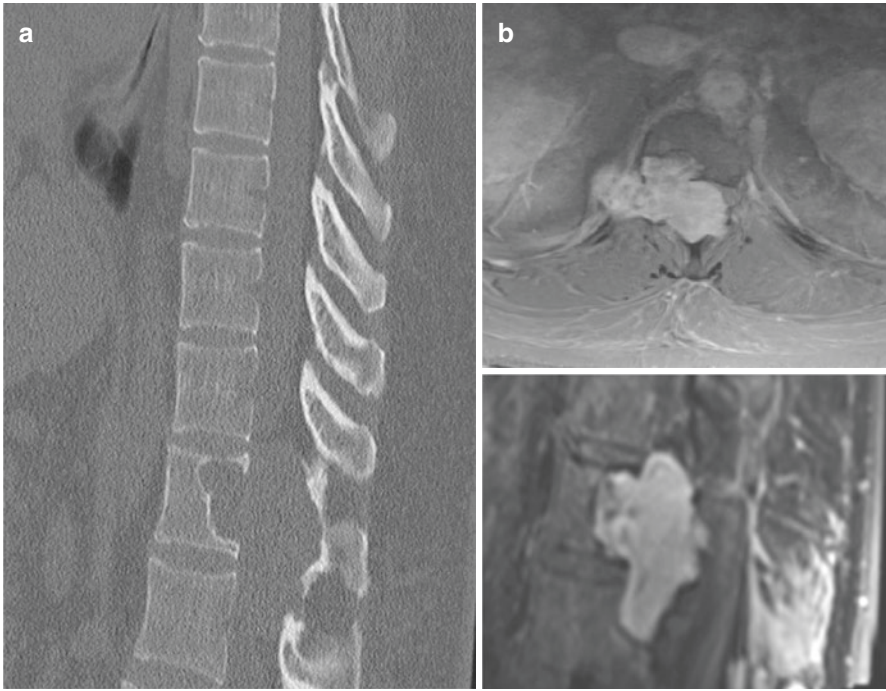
Schwannoma (a) Sagittal CT reformat shows vertebral lytic lesion with large intraspinal component and (b) T1 FS post-contrast axial and sagittal images however shows homogenous enhancing nerve sheath tumor centered around right neural foramen with dumbbell like extraforaminal and intraspinal component along with anterior vertebral body scalloping
